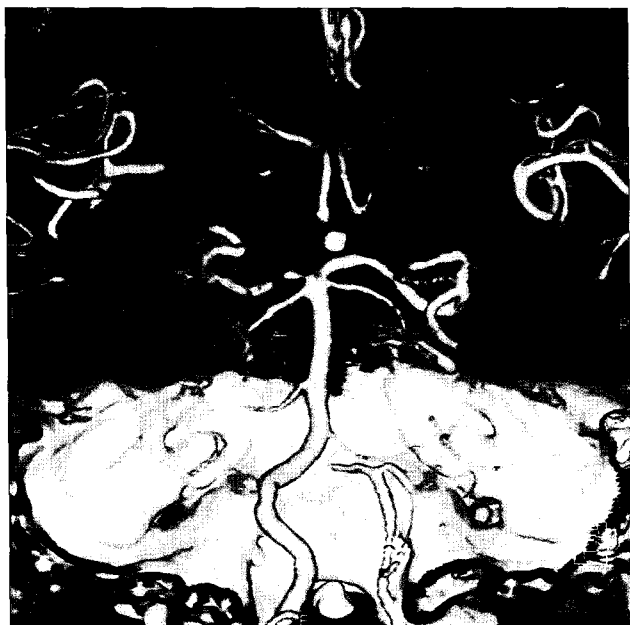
Computed tomography angiography (PA view) revealing the left vertebral artery that is ectatic and medially deviated.
